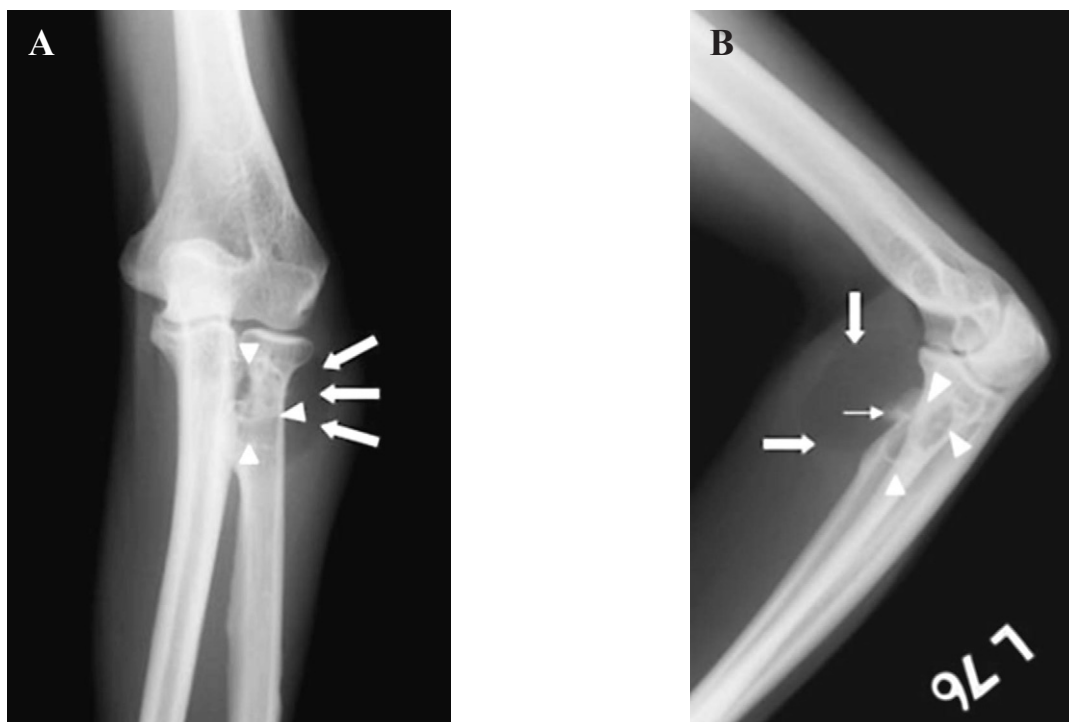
Plain roentgenography of the left elbow. (A) Anteroposterior view shows a radiolucent mass in the proximal forearm, superimposed on the proximal radius (large arrows). A radiolucent zone is also noted in the proximal radius, associated with sclerotic margins (arrowheads). (B) Lateral view shows similar findings. A bony protrusion continuous to the radial cortex is evident (small arrow), suggestive of bony reaction.
